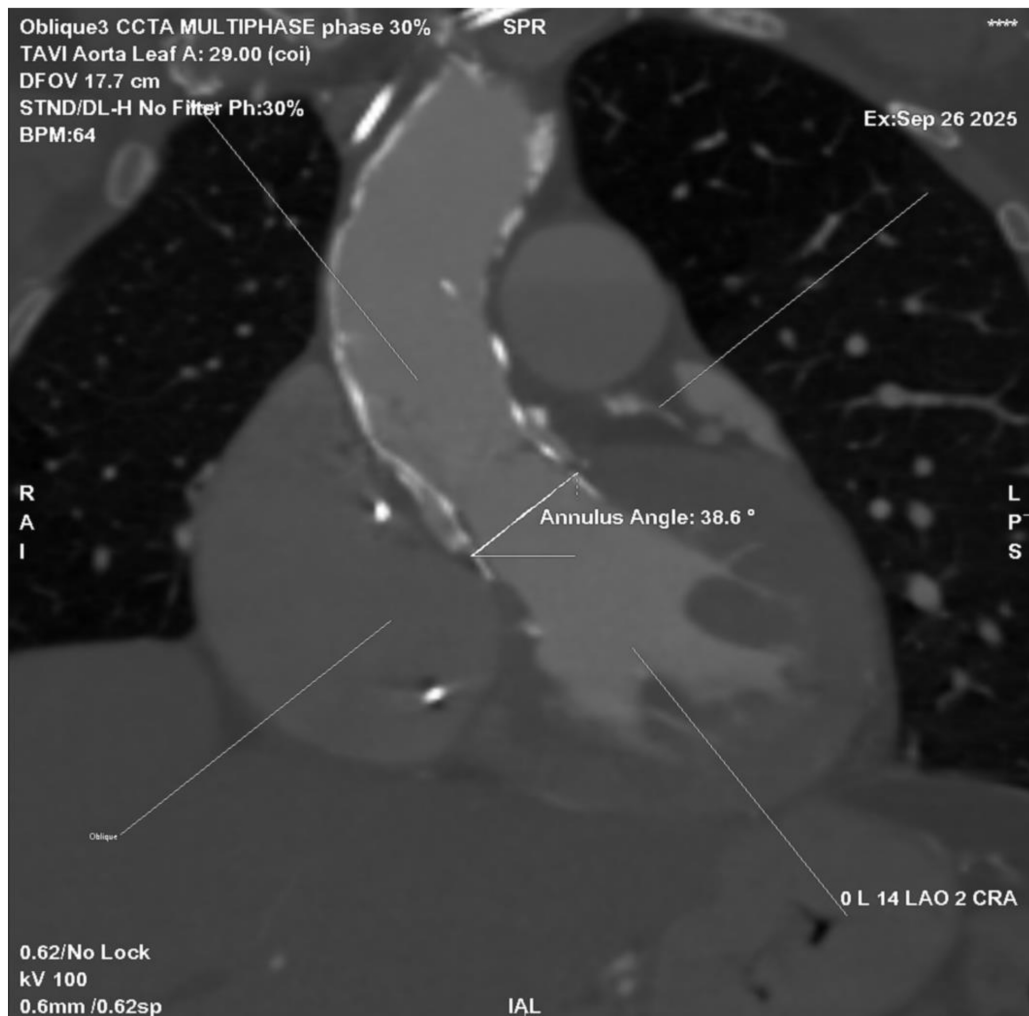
Cardiac CT angiography (CCTA) showing aortic root angulation in the planning of TAVI. Multiplanar reconstruction at 30% of the R–R interval demonstrates an annular angulation of 38.6° , measured between the aortic annulus plane and the horizontal reference line. Accurate assessment of aortic angulation is critical for selecting the optimal fluoroscopic projection and minimizing parallax during valve deployment.
